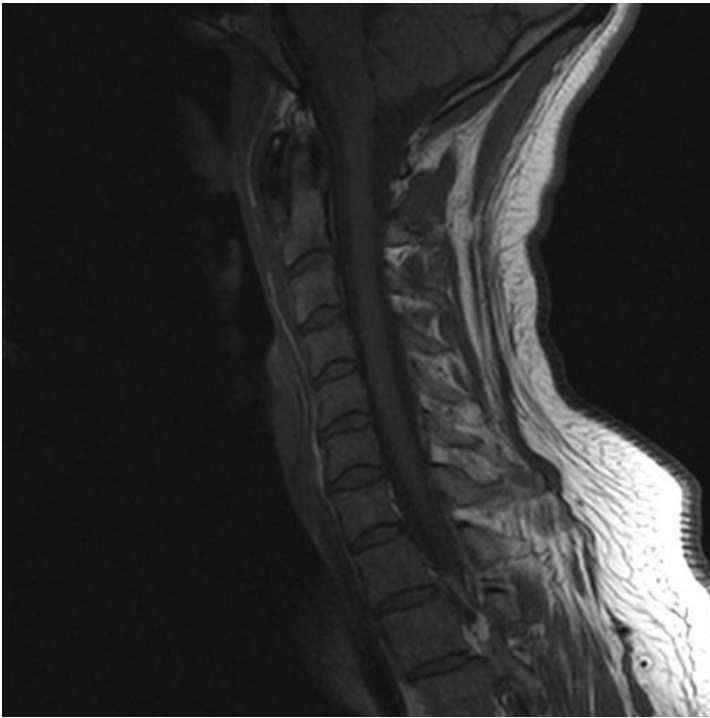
Sagittal T1-weighted image the cervical spine, demonstrating markedly low signal of the globular calcification inferior to the anterior tubercle of C1 and fullness of the adjacent pre-cervical soft tissues.
